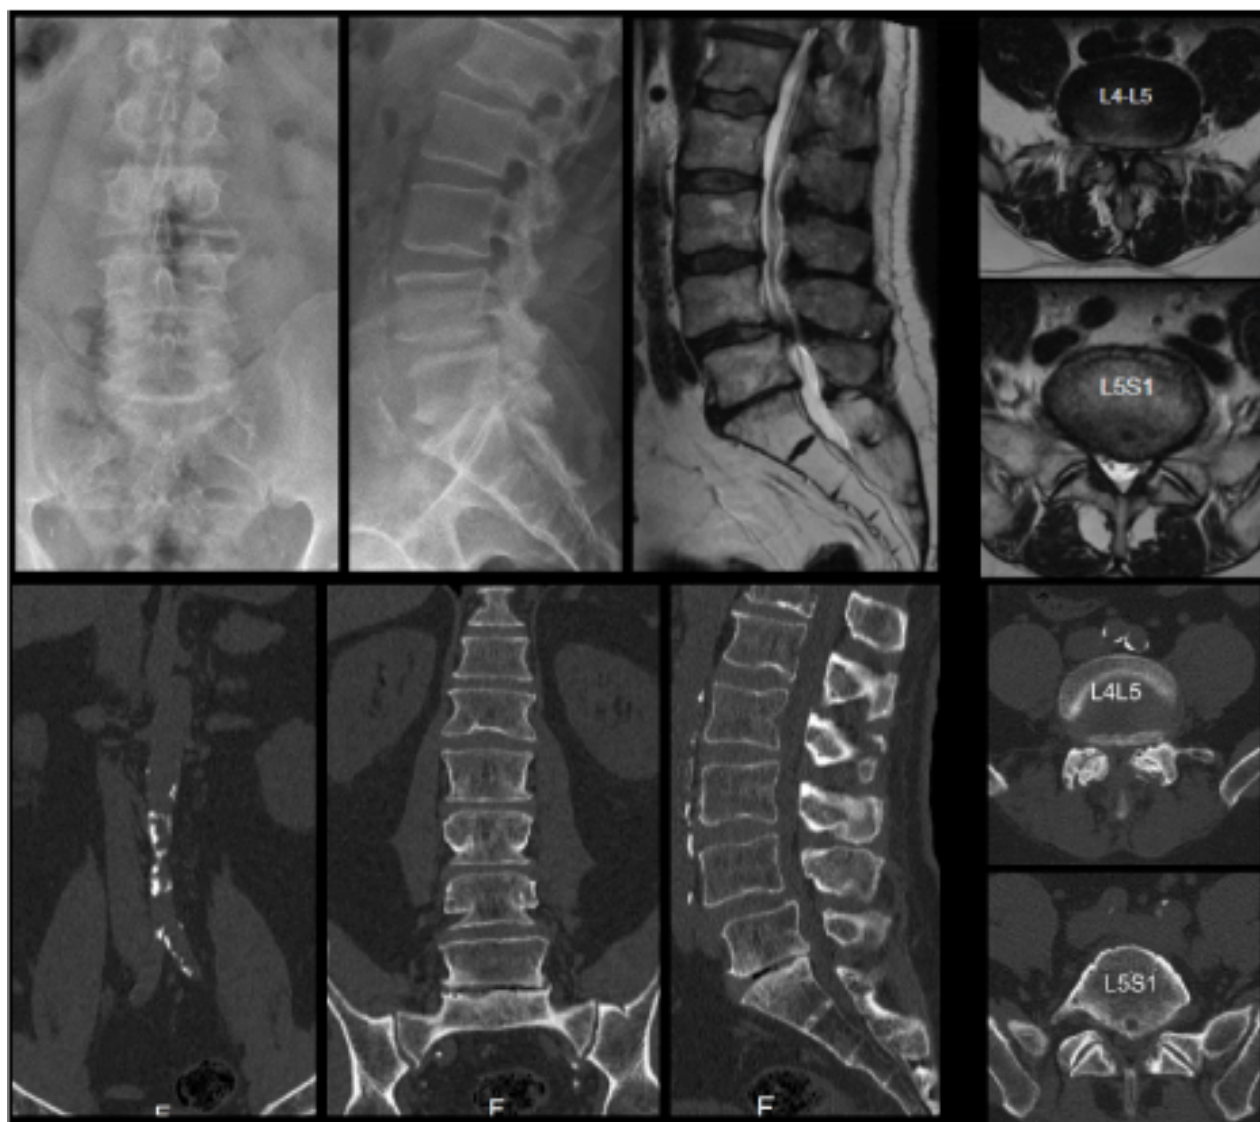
Preoperative X-rays, MRI and CT showing L4-L5 stenosis and degenerative spondylolisthesis with L5-S1 degenerative disk disease.
